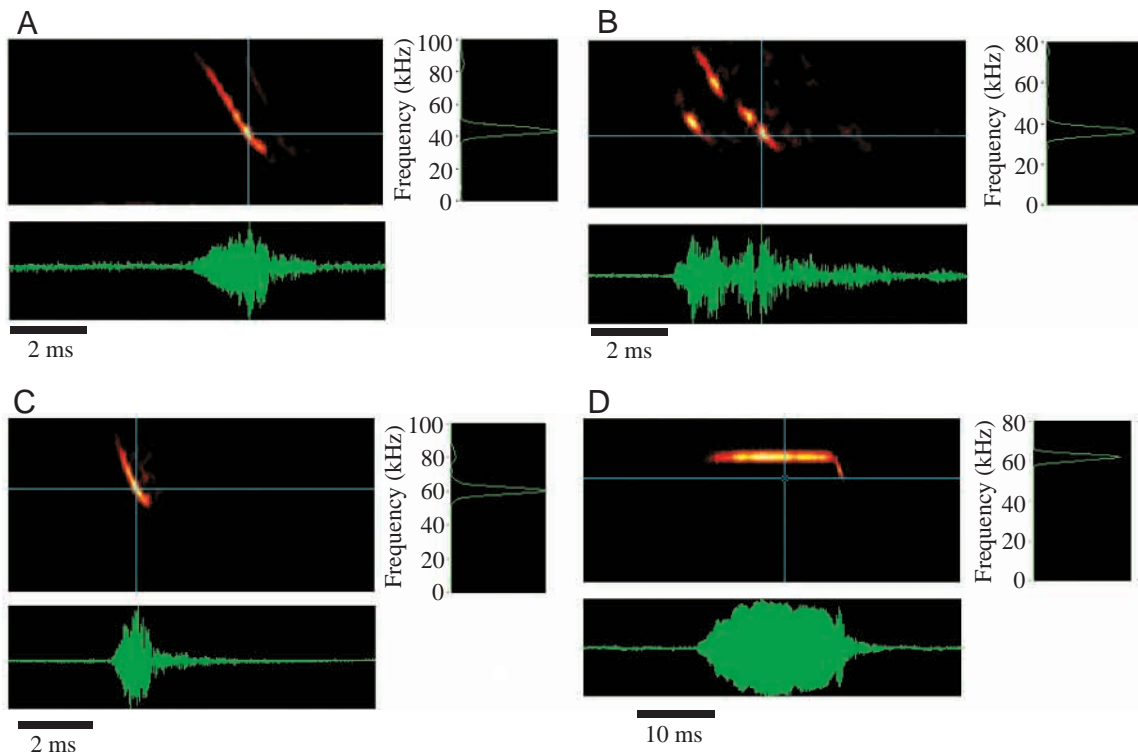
Sonograms (top left), oscillograms (bottom) and Fast Fourier transforms (top right) of biosonar calls recorded at rest. (A) *Myotis myotis*; (B) *Eptesicus serotinus*; (C) *Pipistrellus pygmaeus*; (D) *Pteronotus parnellii*.
